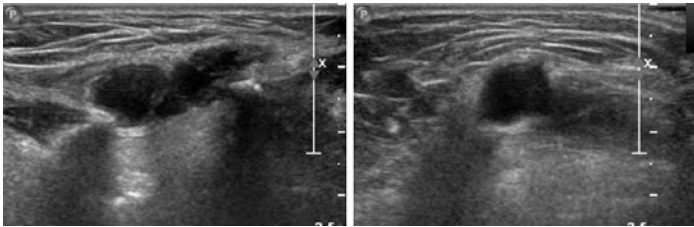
Ultrasound of a midline thyroglossal duct cyst (left panel sagittal, right panel transverse). These well-circumscribed congenital lesions can be confused with prelaryngeal “Delphian” nodes, which can harbor malignancies from laryngeal and thyroid tumors. Thyroglossal duct cysts usually lie along the thyrohyoid membrane, while prelaryngeal nodes are found along the cricothyroid region
